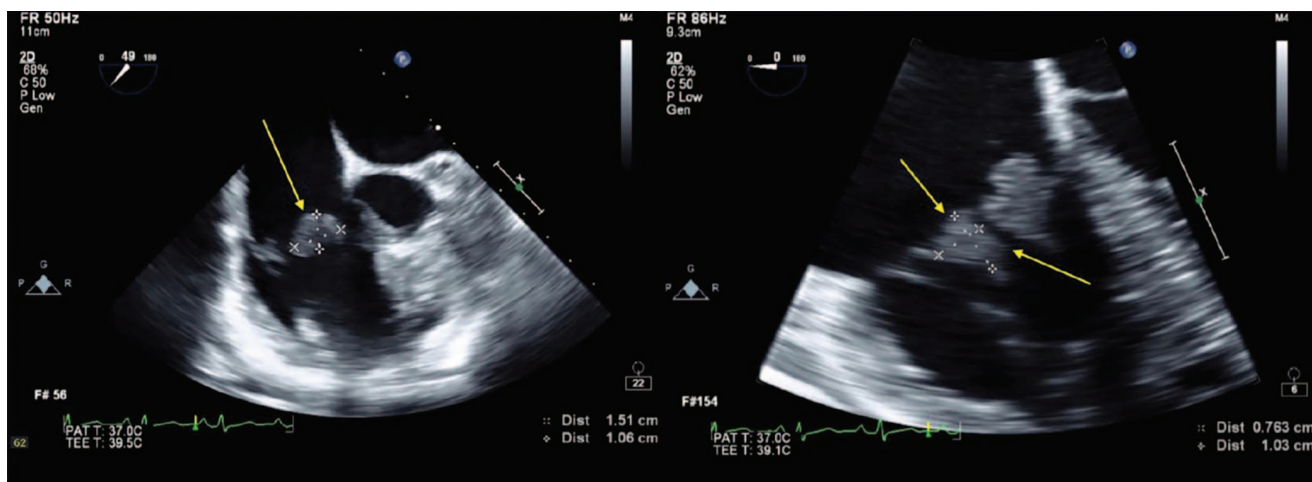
A 44-year-old female patient, secondary antiphospholipid syndrome associated with systemic lupus erythematosus. Transesophageal echocardiogram. On the left: non-bacterial vegetation (marked with an arrow) on the anterior leaflet of the tricuspid valve measuring 1.51×1.06 cm. On the right: vegetation is also visualized on the posterior leaflet of the tricuspid valve measuring 0.76×1.03 cm. Adapted from T. Nagi et al. [43]
